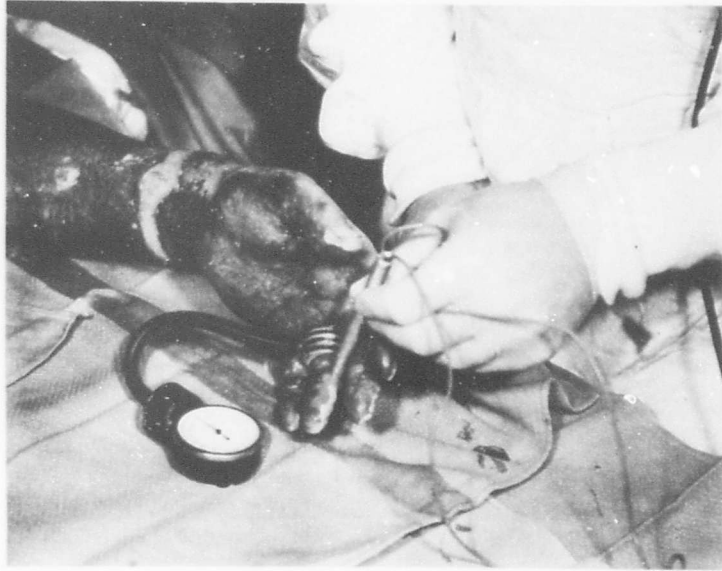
Measurement of arterial pressure measure with Doppler flowmeter and digital blood pressure cuff.
